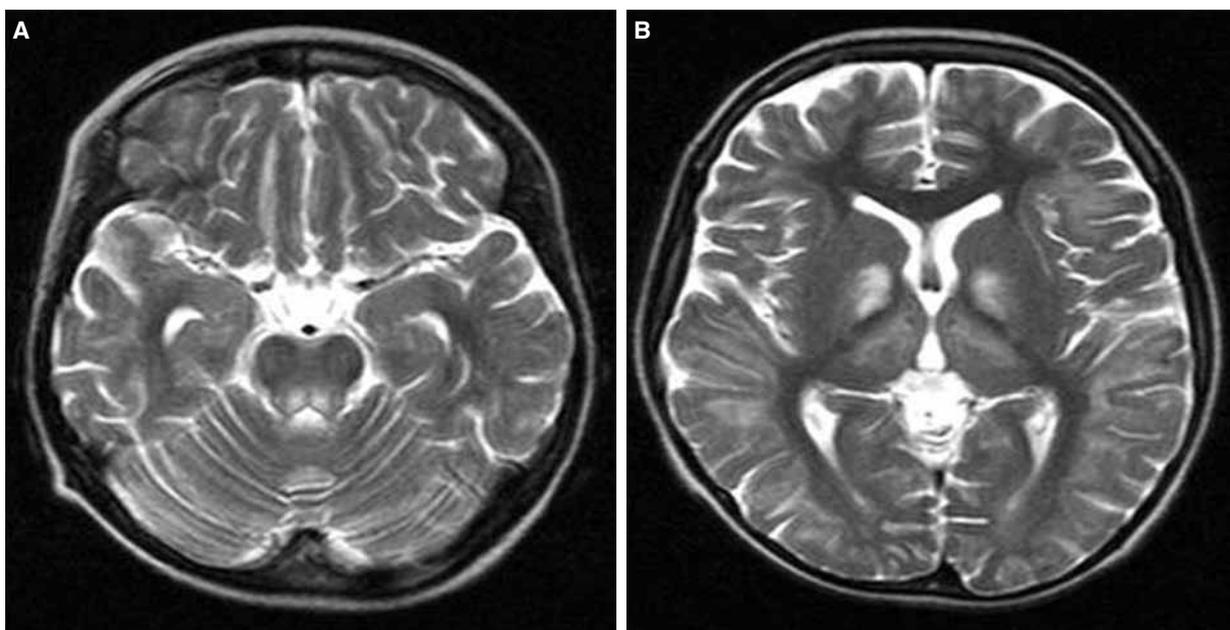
(A, B) Cranial T2-weighted MRI sections showing bilateral lesions with hyperintense signals in the subcortical cerebral white matter, midbrain, thalamus, and putamen.
